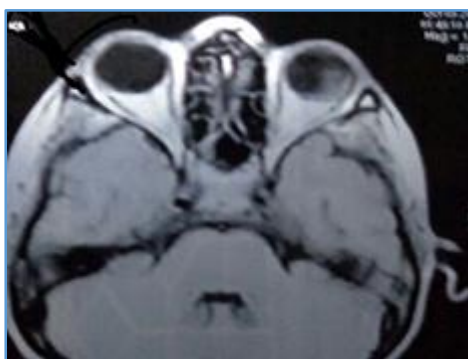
T1 MRI Image Showing Isointense Lesion
